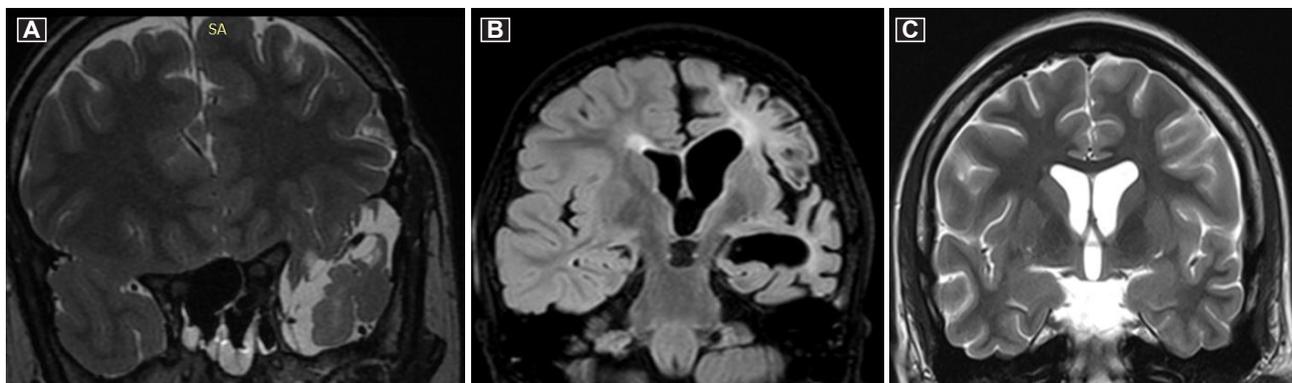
MP-changes on MRI: A – localized changes in the left temporal lobe; B – diffuse changes in the left hemisphere; C – MR-negative
